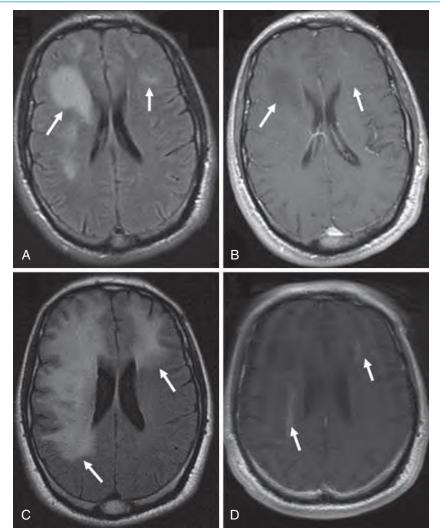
Magnetic resonance images of patient with human immunodeficiency virus infection with classic progressive multifocal leukoencephalopathy at presentation. (A) Fluid-attenuated inversion recovery (FLAIR) image shows lesions in right and left frontal lobes (arrows). (B) No enhancement is evident after gadolinium injection on a T1-weighted image (arrows). (C) FLAIR image after antiretroviral therapy shows progressive multifocal leukoencephalopathy–immune reconstitution inflammatory syndrome displaying progression of lesions in both hemispheres (arrows). (D) Peripheral enhancement can be seen in T1-weighted image after gadolinium enhancement (arrows).
